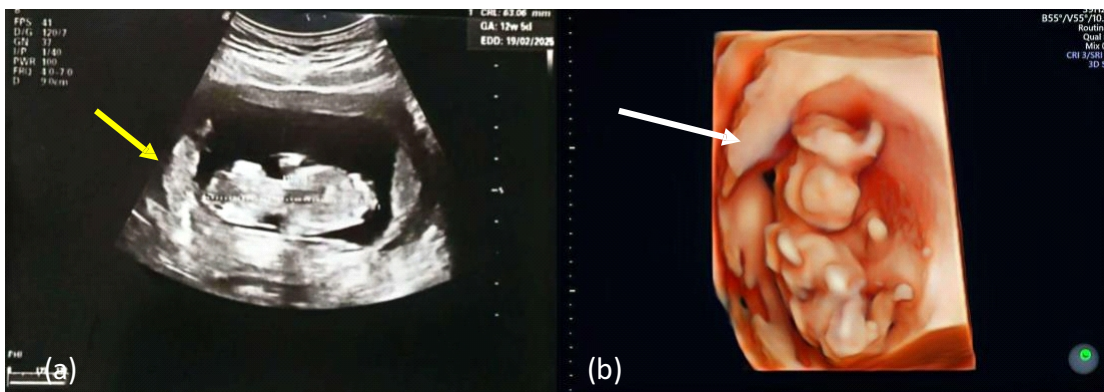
(a) Ultrasonography on coronal plane showed prominent orbital structure with absence of cerebral hemisphere and cranial vault, resembling an appearance of frog eyes (yellow arrow). (b) On 3D ultrasonography examination, absence of cranial vault was clearly shown (white arrow).
